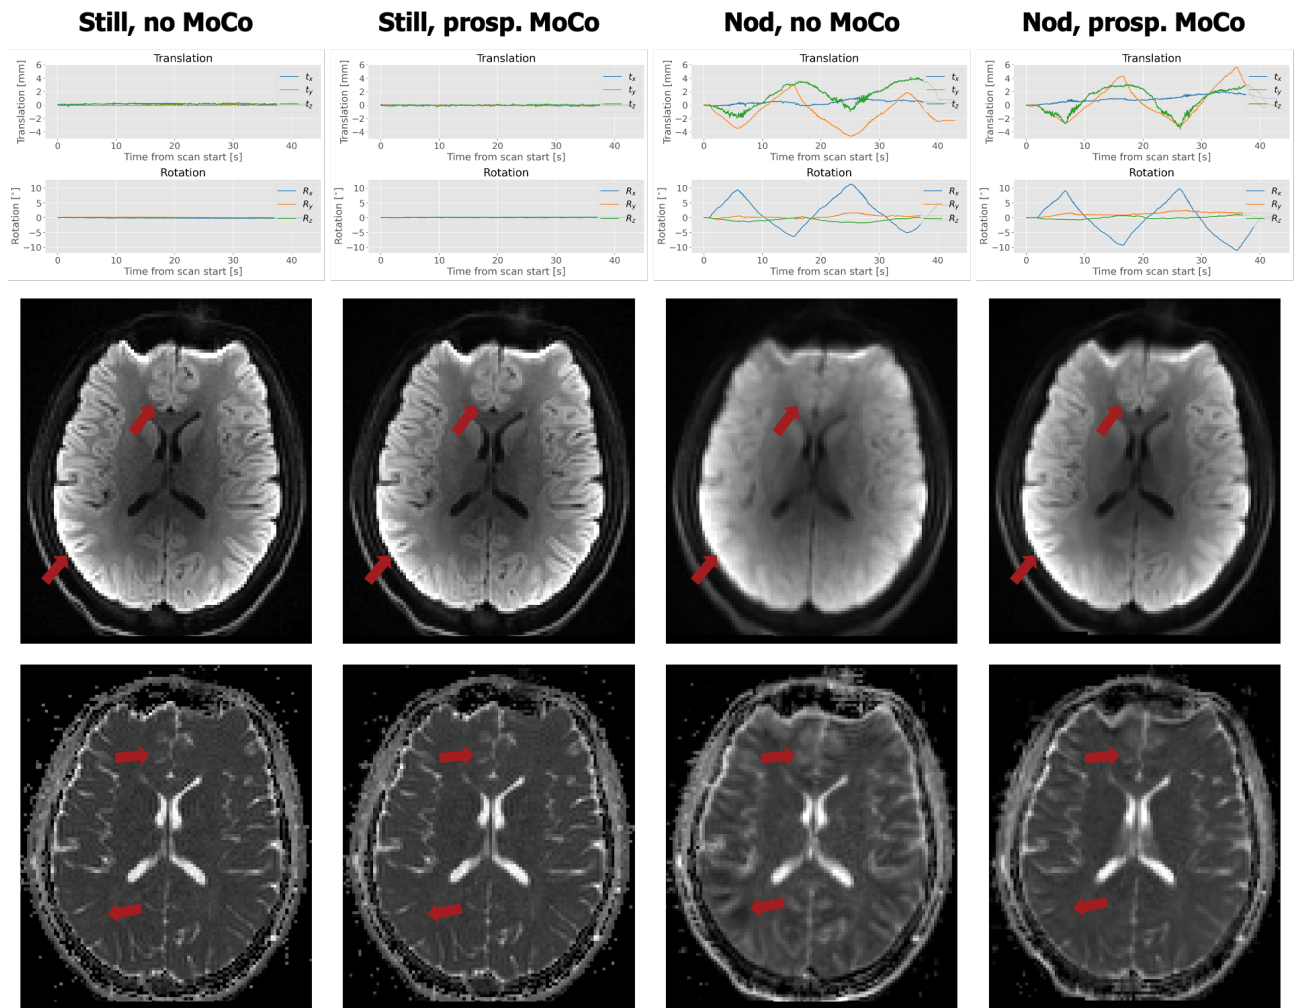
Examples of DWI images, comparing the still and nodding scans with and without pMC (no reacquisition). The motion curves for each scan are shown in the first row, TRACE weighted scans with  $b = 1000 \frac{\text{s}}{\text{mm}^2}$  are shown in the second and ADC maps in the third. Red arrows for TRACE weighted scans show where blurring was decreased and contrast intensified in the nodding scan with pMC. Similarly, for ADC maps red arrows show reduction of artefacts, more precisely areas, where ADC values of the corrected nodding scan are closer to those of the still scans than for the uncorrected scan. All images shown were registered to the still, uncorrected scan.
